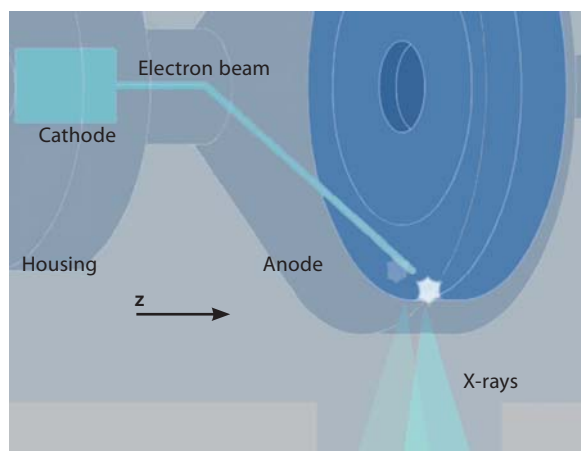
A rotating-envelope X-ray tube (Siemens STRATON, Forchheim, Germany) with z-flying focal spot technique. The entire tube housing rotates in an oil bath. The anode plate is in direct contact with the cooling oil. The central cathode also rotates, and permanent electromagnetic deflection of the electron beam is needed to control the position and the shape of the focal spot. The electromagnetic deflection unit can be used to switch the focal spot between two different positions on the anode plate (indicated by two asterisks). Due to the anode angle of typically $7\text{--}9^\circ$, this translates into a motion both in the radial direction and the z-direction
